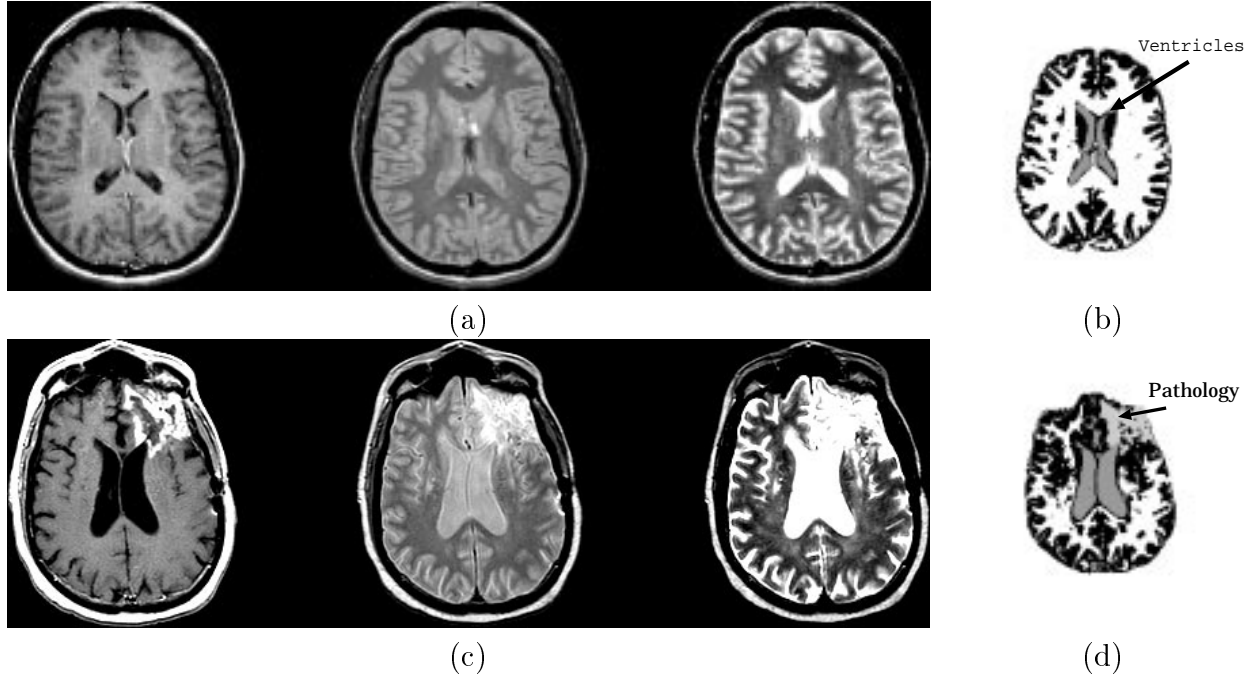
Slices of Interest: (a) raw data from a normal slice (T1-weighted, PD and T2-weighted images from left to right) (b) after segmentation (c) raw data from an abnormal slice (T1-weighted, PD and T2-weighted images from left to right) (d) after segmentation. White=white matter; Black=gray matter; Dark Gray=CSF; Light Gray=Pathology in (b) and (d).
